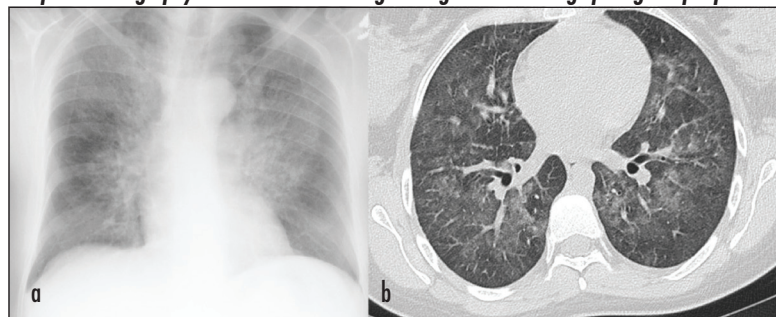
Chest radiograph and computed tomography scan of the chest in a patient with *Pneumocystis jirovecii* infection post-haematopoietic stem cell transplantation. a. Chest radiograph demonstrates bilateral peri-hilar shadowing (bat-wing appearance) and (b) computed tomography scan shows bilateral ground-glass shadowing sparing the peripheries.
